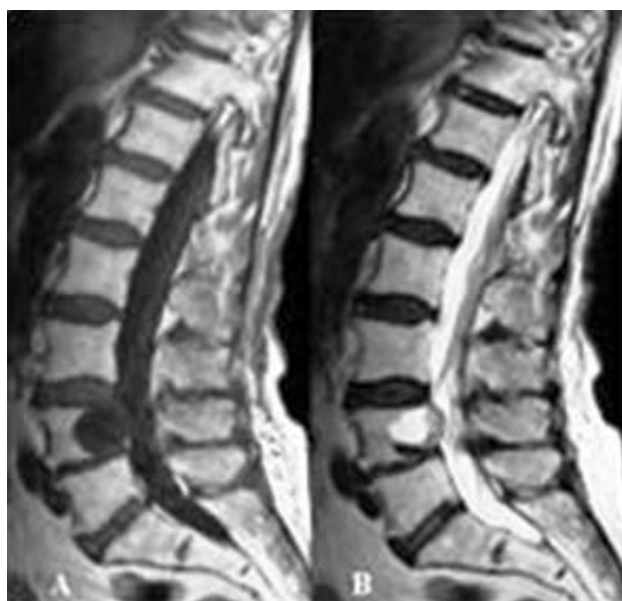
Sagittal MRI views of a neurofibroma at the level of L4: A) T1 – hypointense signal; B) T2 – hyperintense signal with a focal zone of hypointense signal.
